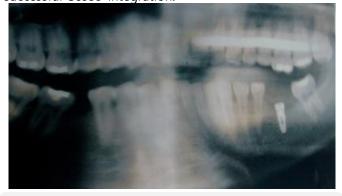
Orthopantomograph showing the placement of the Implant
